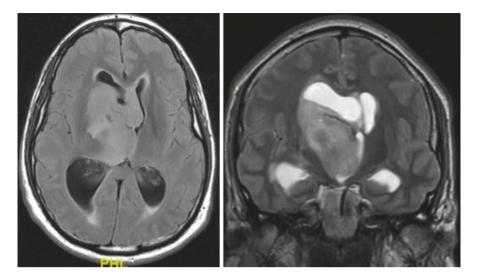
Basal ganglia tumor: Axial FLAIR and coronal T2 MRI showing a right basal ganglia and forniceal tumor in a 29-year-old. The patient underwent an endoscopic septostomy—biopsy and a shunt. Pathology was an anaplastic astrocytoma. Patient was treated with chemotherapy and radiation
